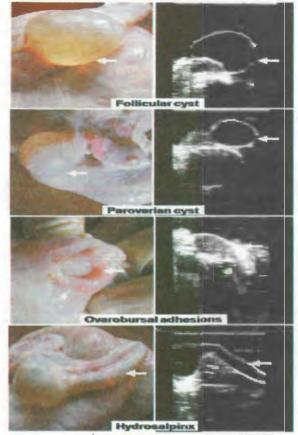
Photographs (left) and sonograms (right) of ovarian and fallopian tube abnormalities in buffalo genitalia
